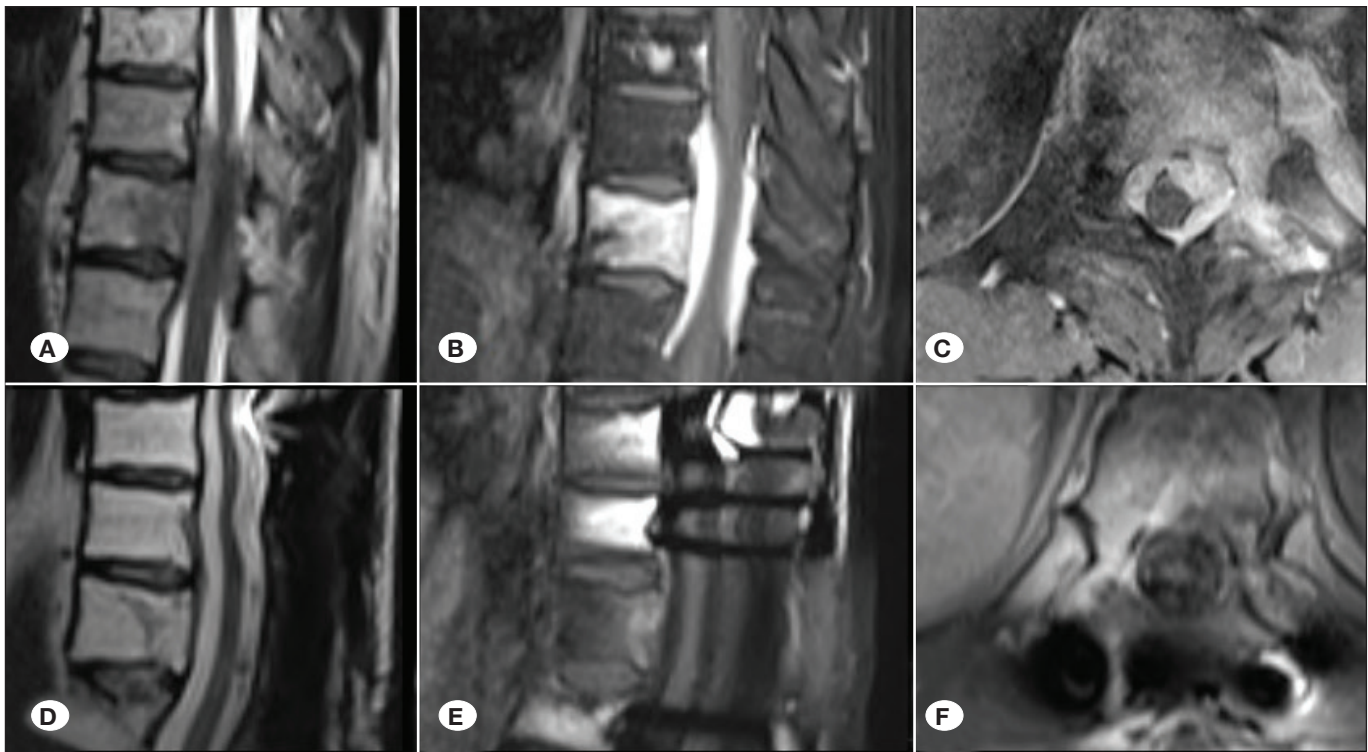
Sagittal T2 weighted (A), sagittal postcontrast T1 weighted (B) and axial postcontrast T1 weighted (C) MR images of a case with low back pain and progressive paraparesis showed presence of tumor compressing the spinal cord circumferentially at level of T11-12. Open biopsy, decompression and stabilization performed to the patient. The patient improved neurologically and referred to the hematology. One year later, sagittal T2 weighted (D), sagittal post-contrast T1 weighted (E) and axial post contrast T1 weighted (F) MR images showed no tumor.
